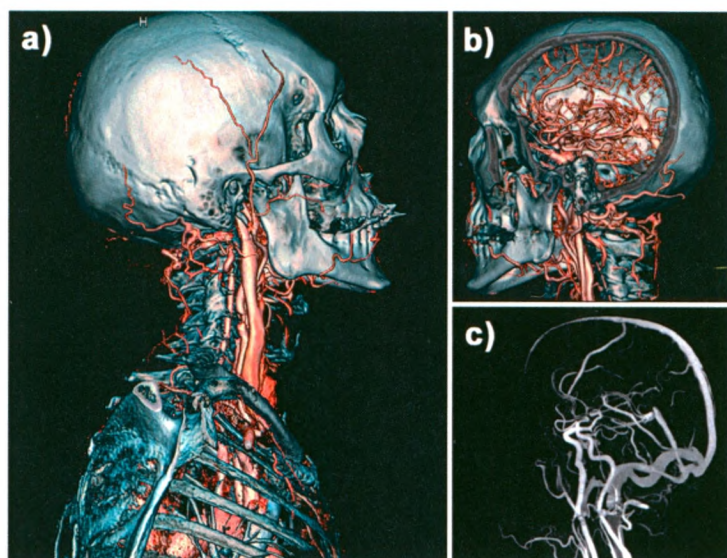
(a,b) Volumes rendered CT images, showing bone-iodine separation using Siemens' Somatom Definition dual-source CT device. (c) Volume rendered iodine only image. X-ray tubes operate at 80 and 120 kVp. Permission obtained by David Menary, Internal Communications, Siemens Canada Limited.
